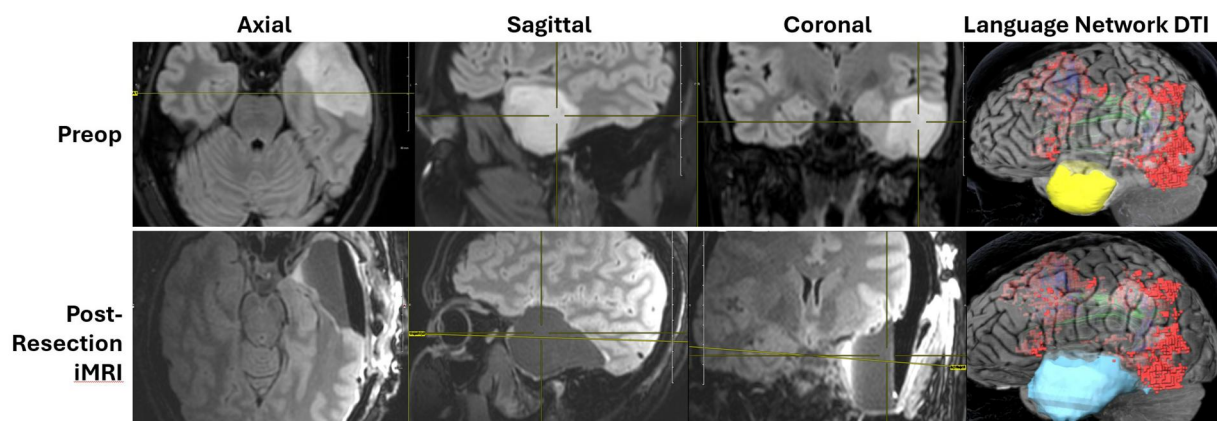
Pre- and postoperative FLAIR MRIs from a 35-year-old right-handed female who presented with a first-time seizure demonstrating a supramarginal resection of a grade 3 IDH-mut astrocytoma. Yellow – preoperative tumor volume. Blue – postoperative resection cavity.
